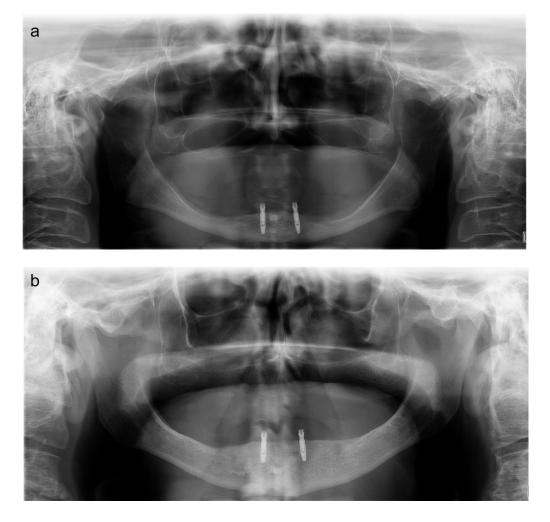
Panoramic radiograph after MO installation: a.) atrophic patient; b) non-atrophic patient.
